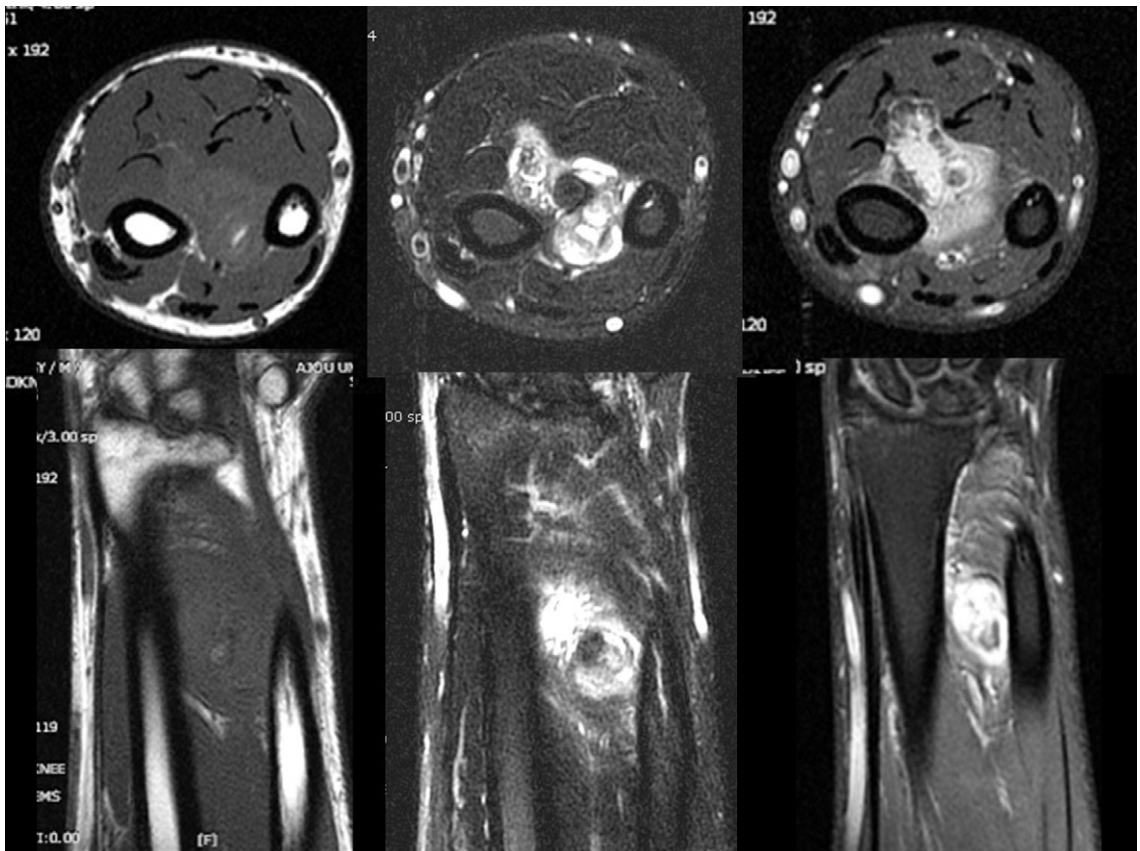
Magnetic resonance imaging shows the mass showed nodular high signal intensiteis on precontrast images, heterogenous enhancement was noted after contrast enhancement. The center of mass seemed to be located among flexor pollicis longus, flexor digitorum and interosseous membrane.
